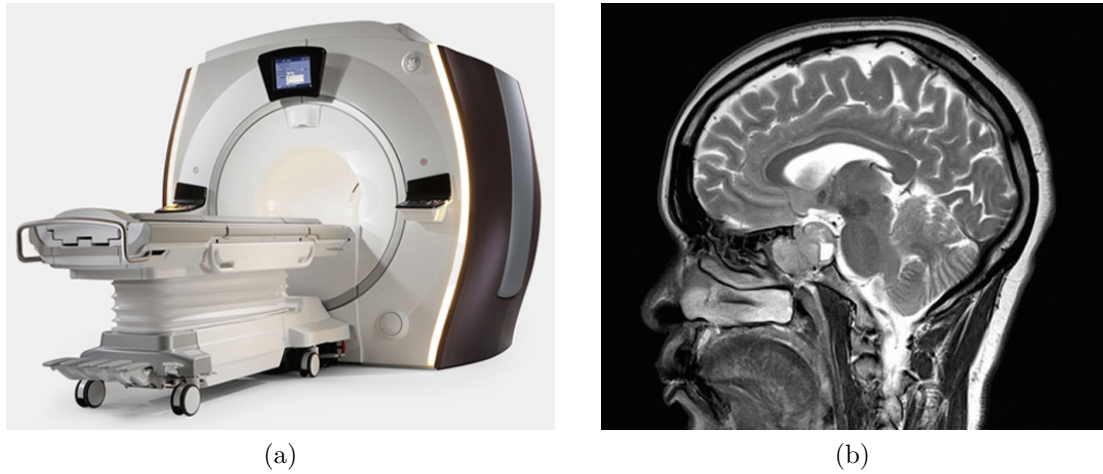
(a) MRI scanner, Optima™ MR450w GEM-70cm. (b) MRI image of a brain showing a pituitary tumour<sup>2</sup>.
